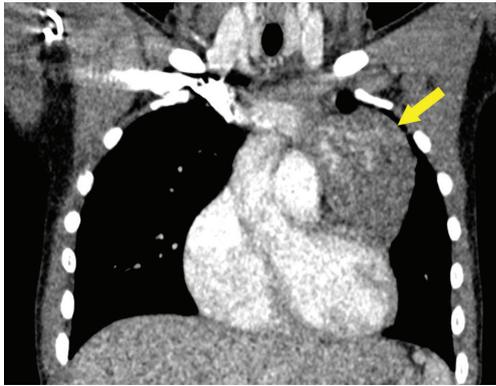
Case 1 imaging. Coronal contrast-enhanced pediatric protocol low dose CT showed a left prevascular mediastinal mass (arrow) that is well-circumscribed, and lobulated, with serpiginous heterogeneous enhancement. CT, computed tomography.
